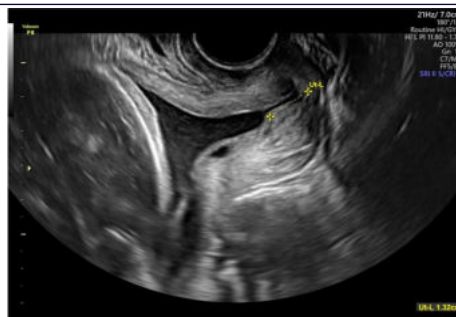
Short cervical length (1.32 cm) with open internal os on transvaginal sonography (TVS)
